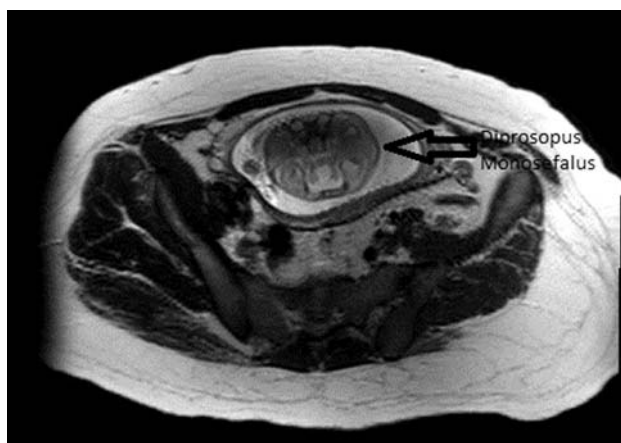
MRI view of double-face, single head.
